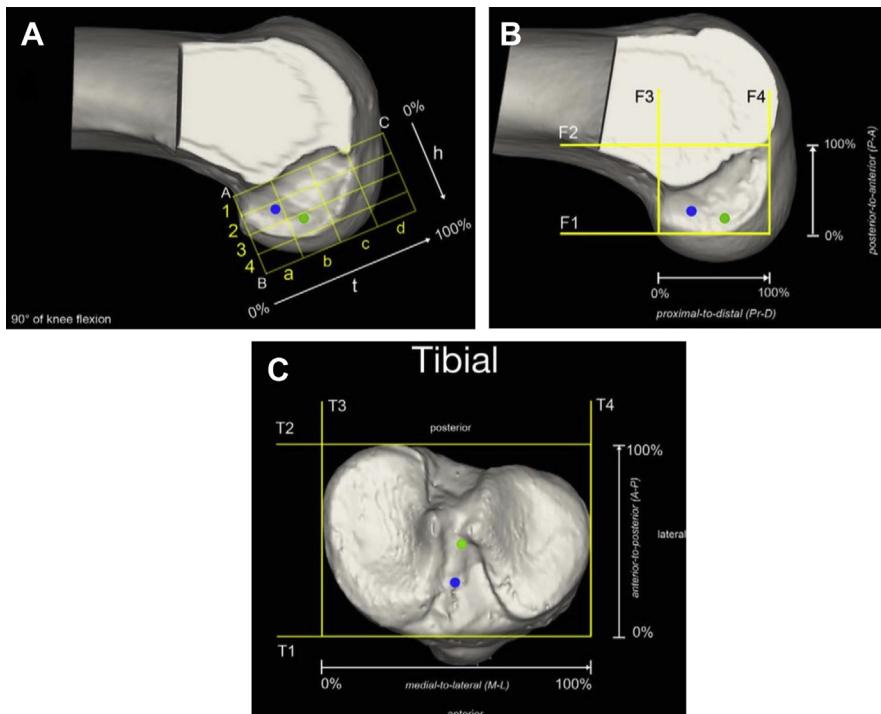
Three-dimensional CT evaluation of the femoral and tibial tunnel location. Anatomic AM tunnel position: (blue); anatomic PL tunnel position: (green). (A) Quadrant method (for femoral side): the locations of the femoral tunnels are established within a 4×4 grid, which is oriented along the most anterior edge of the notch roof, parallel (t) and perpendicular (h) to the Blumensaat line. (B, C) Anatomic coordinate axes method (for the femoral and tibial sides): the locations of the tunnels are determined in the axial and sagittal planes, aligned with the respective bone anatomic axes. Lines: F1—posterior border of the medial wall of the lateral condyle; F2—most anterior point of the notch; F3—proximal border of the notch; F4—distal point of the notch roof; T1—anterior border of the tibial plateau; T2—most posterior border of the tibial plateau; T3—medial border of the tibial plateau; T4—lateral border of the tibial plateau. Axes: Femoral side—posterior-to-anterior (P-A) = F1 to F2; proximal-to-distal (Pr-D) = F3 to F4. Tibial side: anterior-to-posterior (AP) = T1 to T2; medial-to-lateral (ML) = T3 to T4. (Adapted from Forsythe B, Kopf S, Wong AK, et al. The location of femoral and tibial tunnels in anatomic double-bundle anterior cruciate ligament reconstruction analyzed by three-dimensional computed tomography models. J Bone Joint Surg Am 2010;92:1418–26; and Kopf S, Forsythe B, Wong AK, et al. Nonanatomic tunnel position in traditional transtibial single-bundle anterior cruciate ligament reconstruction evaluated by three-dimensional computed tomography. J Bone Joint Surg Am 2010;92:1427–31.)
